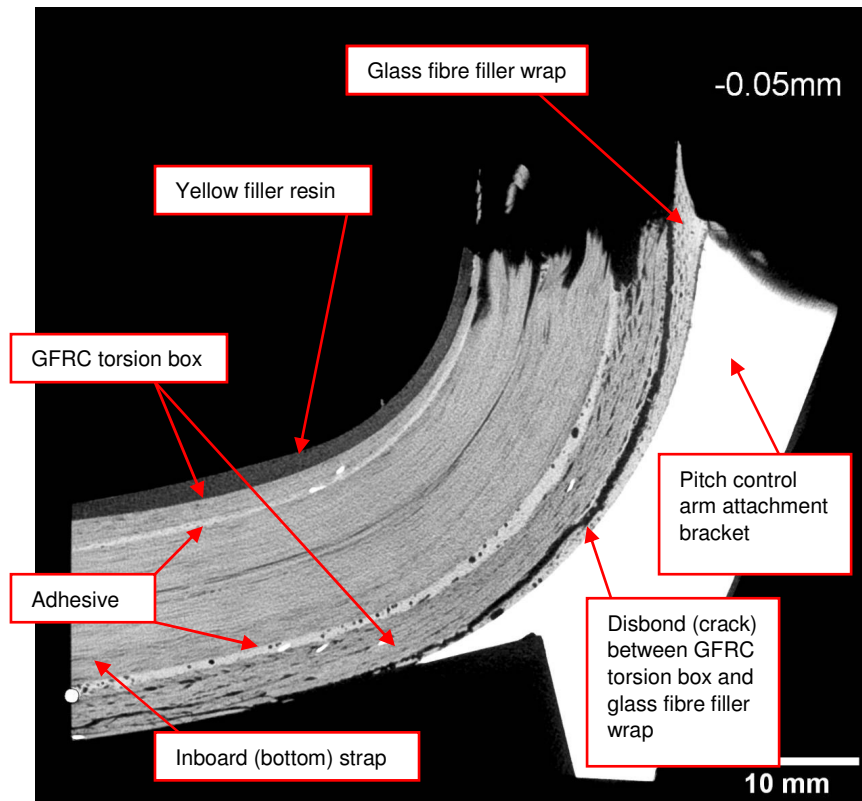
X-ray tomography image showing a side-view slice through the bottom (inboard) strap of the White blade, trailing edge fracture location, approximately 3.5 mm from the inboard edge of the blade arm
